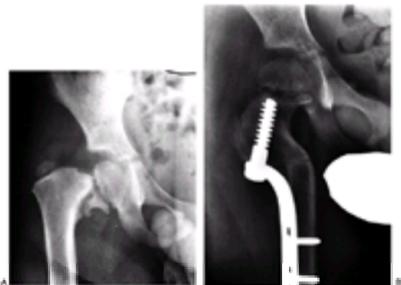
Anteroposterior radiographs of a hip affected with developmental coxa vara. A: The preoperative radiograph demonstrates a classic inferior femoral neck triangular fragment. B: Three months postoperatively, the radiograph demonstrates correction of the physeal angle, with spontaneous closure of the femoral neck triangular metaphyseal fragment.
